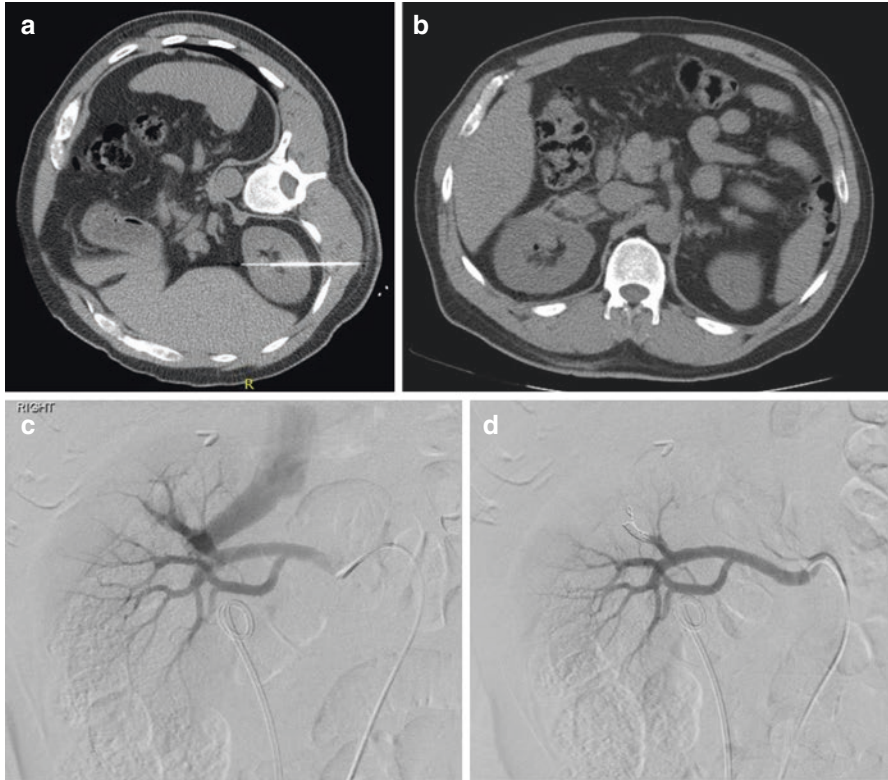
(a) CT-guided right renal mass biopsy. (b) Post-procedure CT scan showing a very mild anterior subcapsular hematoma. (c) Early filling of the right renal vein on arteriogram suggestive of an arteriovenous fistula. (d) Successful fistula coil embolization
